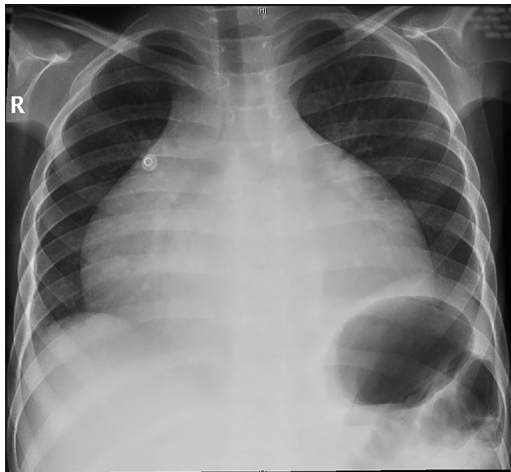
Chest radiograph showing massive cardiomegaly with predominant right atrial enlargement. Pulmonary venous hypertension is absent and there is no pleural effusion
